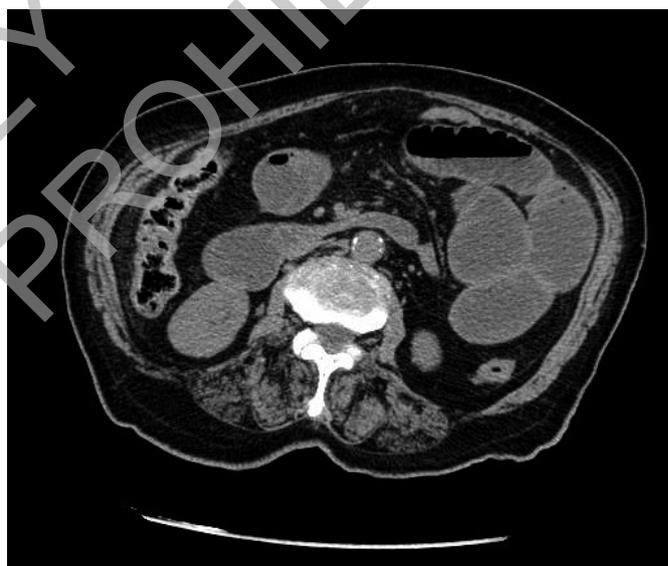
Preoperative CT scan showing air-fluid levels and distension of intestinal loops.
